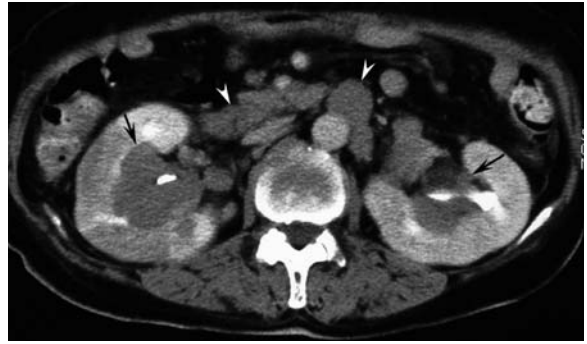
Peripelvic lymphoma in a 63-year-old woman. Axial contrast-enhanced CT scan shows soft tissue density masses involving the renal sinus of both kidneys (arrows). Multiple retroperitoneal lymph nodes (arrowheads) are also seen.
